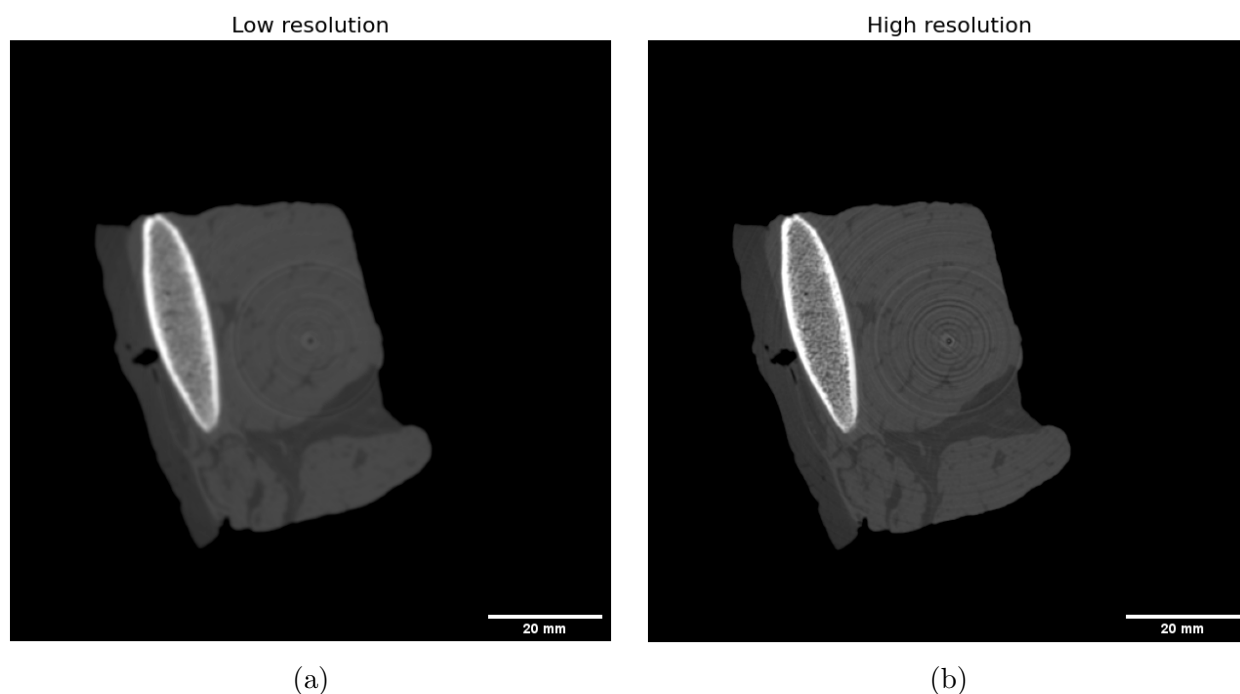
Spatial resolution. CT slice of an *ex-vivo* tissue sample with (a) low resolution (b) high resolution.
